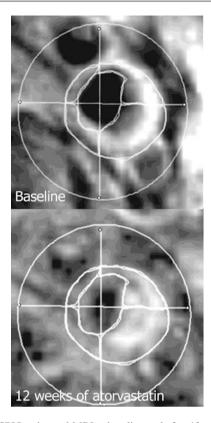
USPIO-enhanced MRI at baseline and after 12 weeks of atorvastatin therapy. Note the increased enhancement in the *right upper* and *lower quadrant* signifies a lower USPIO accumulation, thus, reduced inflammatory process
